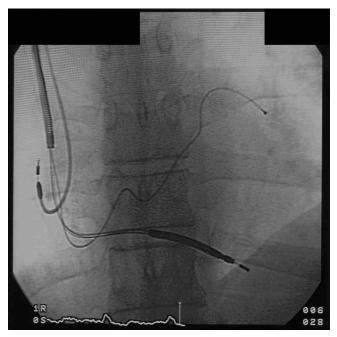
X-ray showing final position of all three leads, including the Corox LV-H (Biotrionik) in the coronary sinus.
